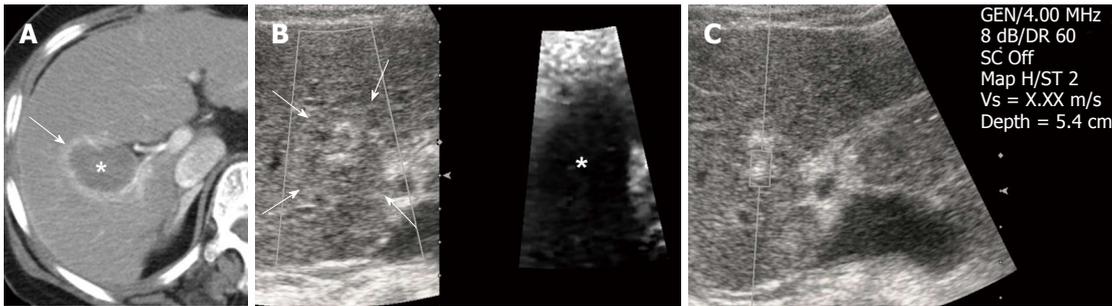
Post-radiofrequency ablation hepatocellular carcinoma in a 71-year-old woman with underlying liver cirrhosis. A: Contrast-enhanced arterial phase computed tomography scan obtained immediately after radiofrequency ablation (RFA) shows the ablation zone of low attenuation (asterisk) with a surrounding ring of benign enhancement (arrows) in segment 5 of the liver; B: Next day, follow up B-mode image of post-RFA hepatocellular carcinoma (HCC) is seen as an ill-defined heterogeneous echogenic lesion (arrow) and the HCC appears darker on the acoustic radiation force impulse image (asterisk); C: The shear wave velocity of post-RFA HCC is uncheckable, shown as X.XX m/s. GEN: General; SC: Spatial compounding; Vs: Velocity.
